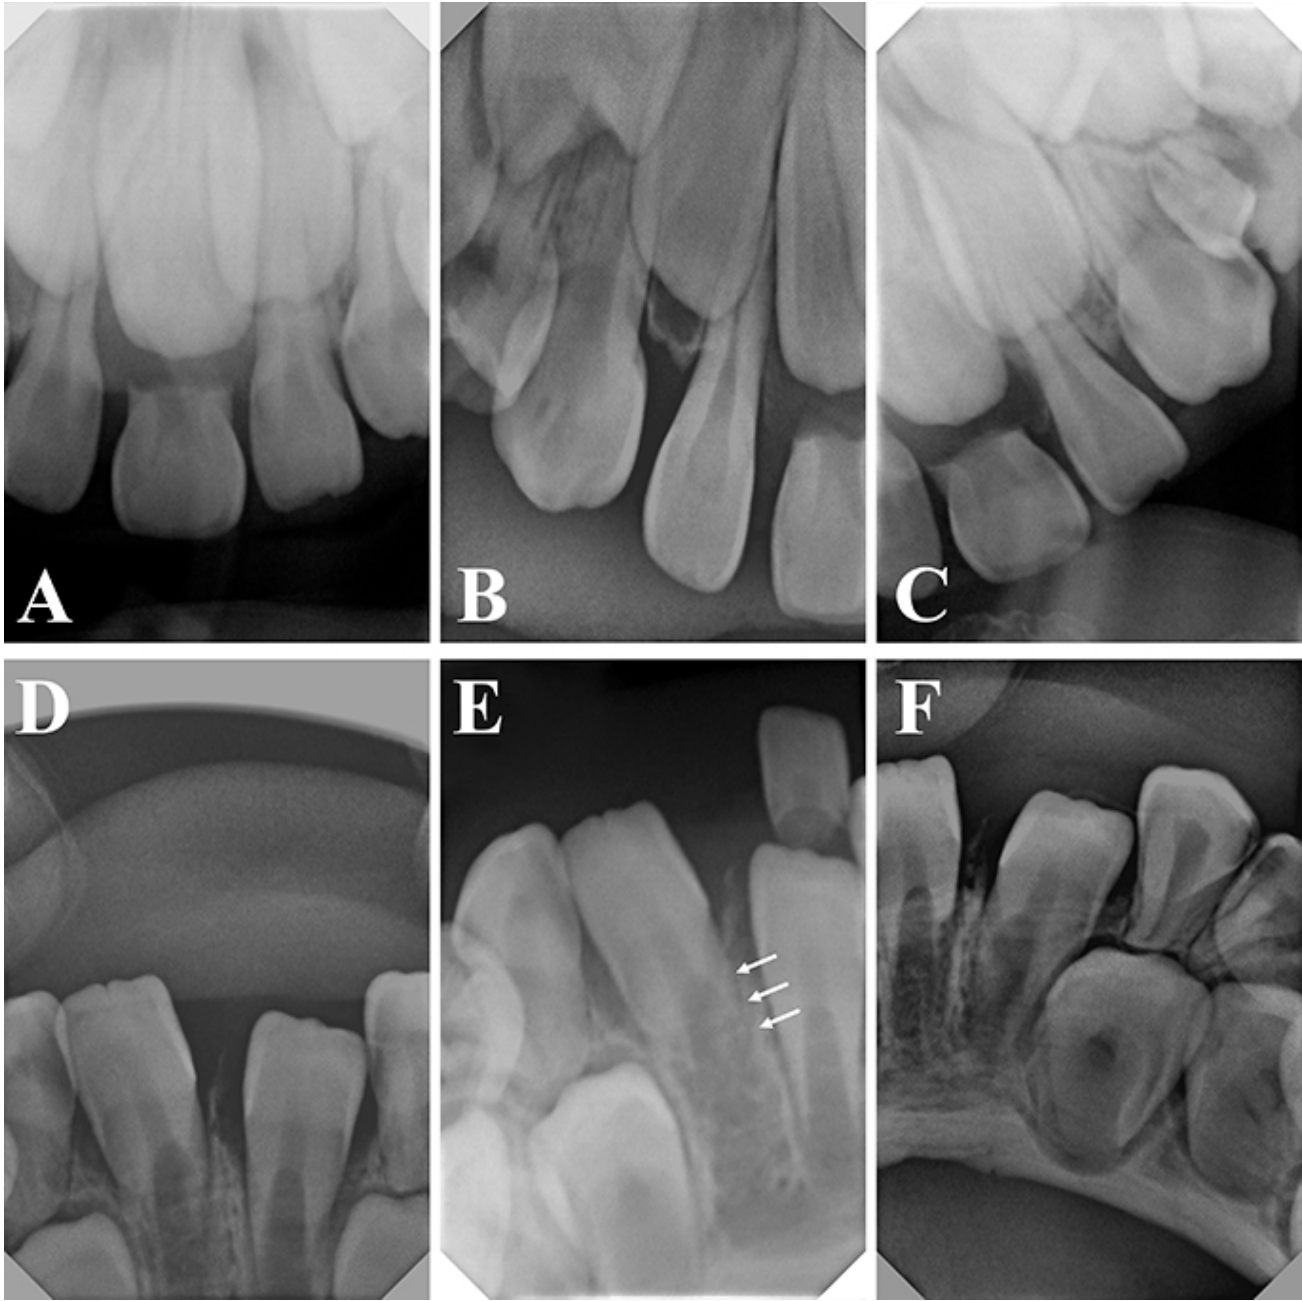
Anterior Periapical Radiographs. (A–C) Periapical radiographs of the anterior maxillary area. (A) A rootless primary solitary median maxillary central incisor (SMMCI) and succedaneous permanent SMMCI. (B) Right maxillary lateral incisor area. (C) Left maxillary lateral incisor area. (D–F) Periapical radiographs of the mandibular anterior area. (D) Hypodontia of the permanent mandibular central incisors and presence of the permanent mandibular lateral incisors with delayed root development (white arrows). (E) Right mandibular lateral incisor area. (F) Left mandibular lateral incisor area. Figs. 5D and 5F were taken after the exfoliation of tooth number 72.
